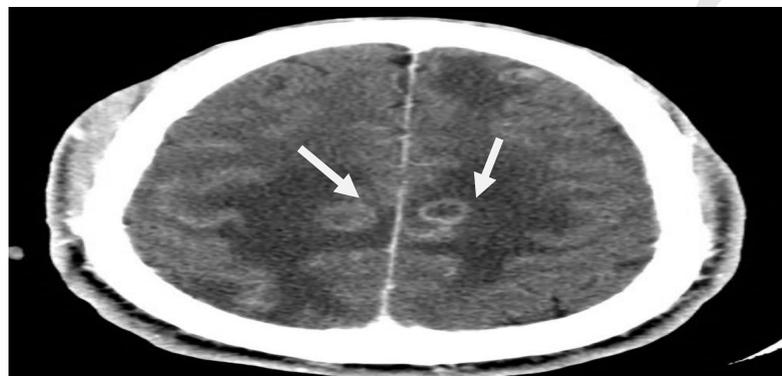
CT brain shows multiple enhancing brain lesions, 32years, a male patient HIV and CNS toxoplasmosis with CD4 count 50 cells/mm³.
